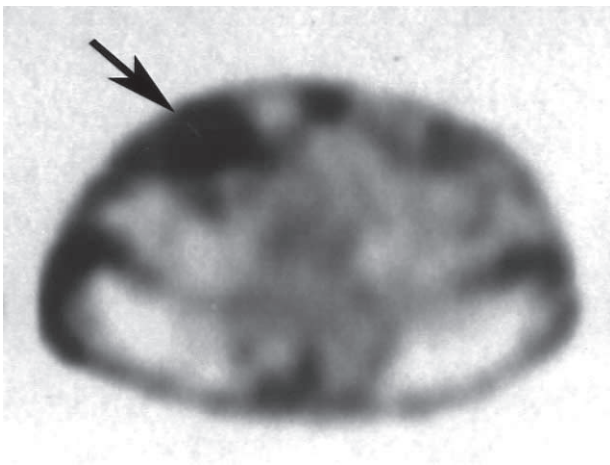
The SPECT transaxial section shows the lesion is located at the right low abdominal wall extending to the deep layer (*arrow*).
